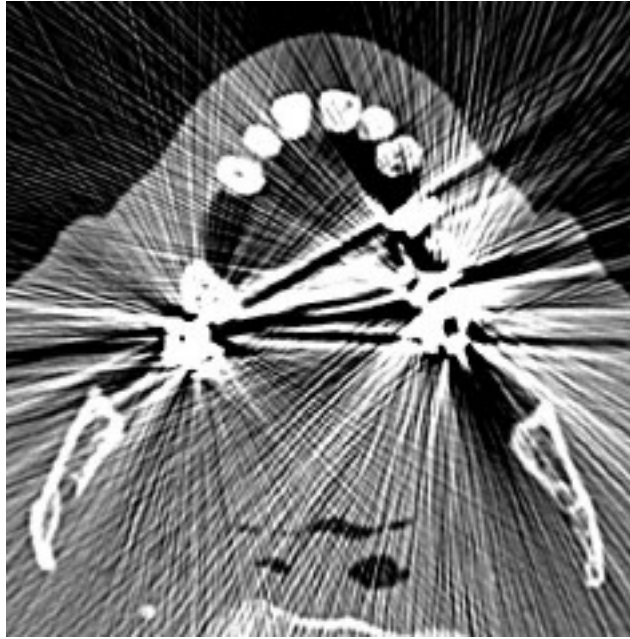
Sample of metal artifacts on CT image [1.40]
